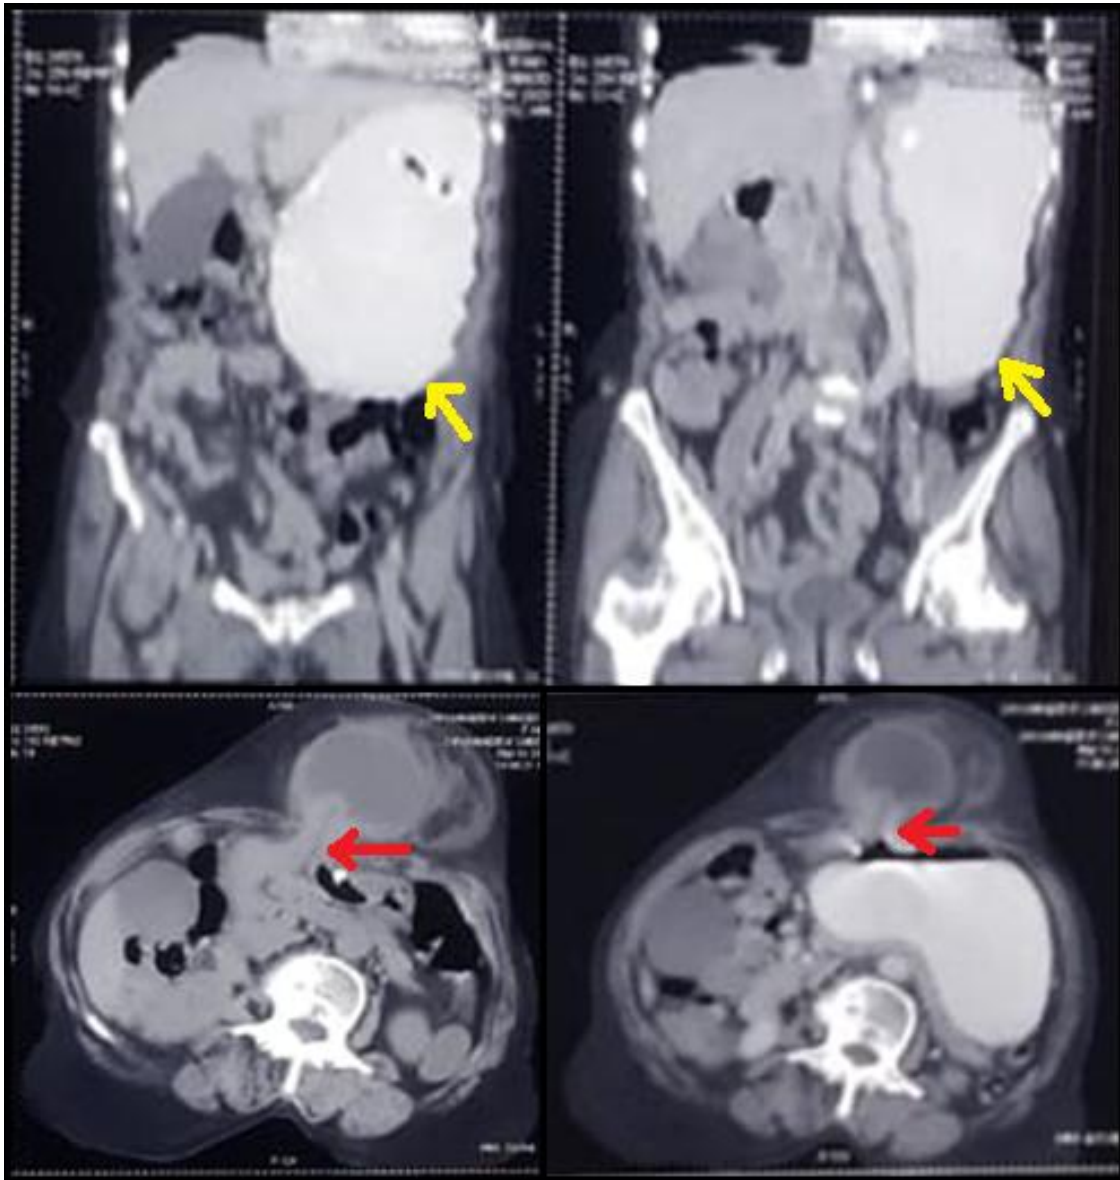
Contrast enhanced CT revealing herniation of distal stomach through the anterior abdominal musculature (red arrow) with a grossly dilated proximal stomach (yellow arrow) with oral contrast
